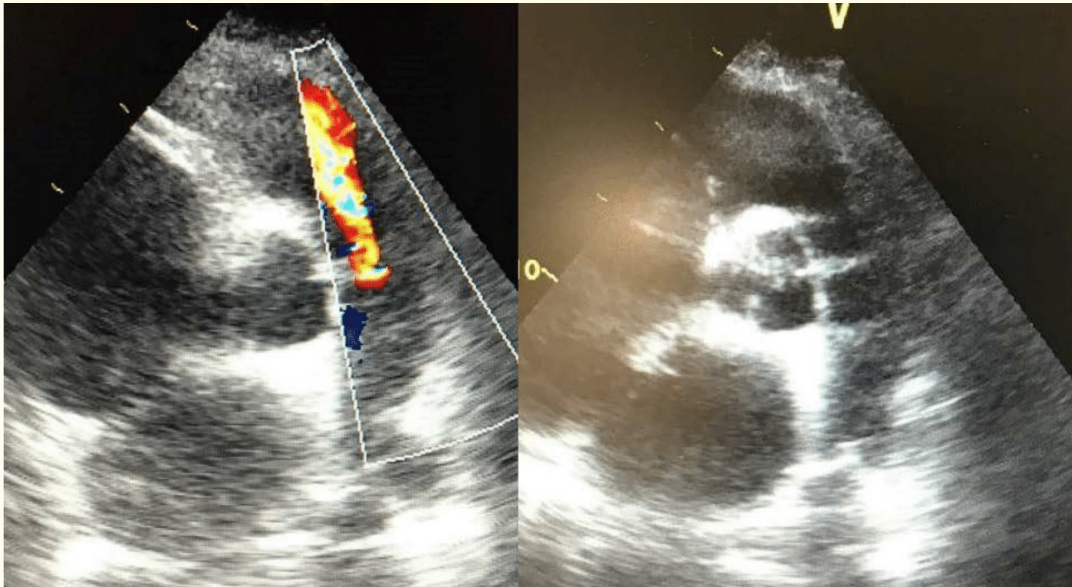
TTE parasternal short axis view showing mild pulmonary stenosis and moderate regurgitation.
